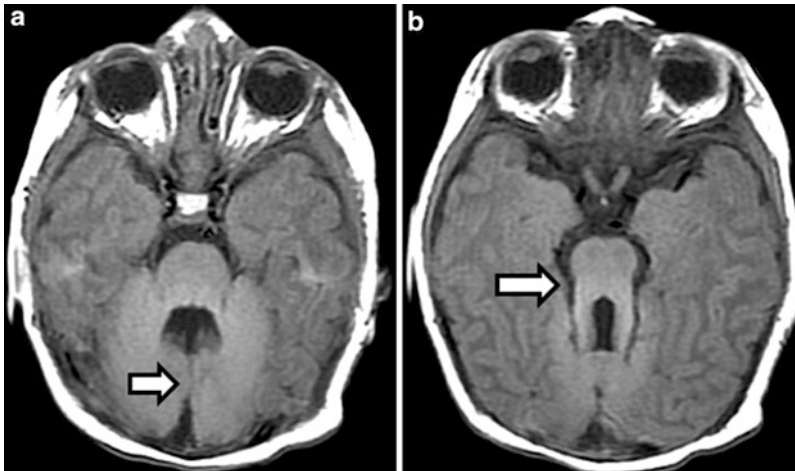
(a, b) A 5-day-old boy was presented with exaggerated periodic breathing and developmental delay. The MRI of the brain demonstrated the absence of the vermis (a) (arrow) with enlarged superior cerebellar peduncles producing a molar tooth configuration of the midbrain (b) (arrow). The findings are compatible with Joubert syndrome. Genetic tests showed that this patient was
